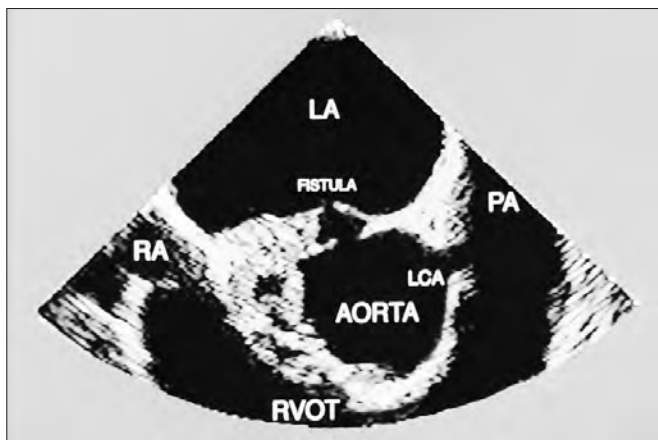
Transesophageal echocardiography showing the aorta to left atrial fistula. LA = left atrium, RA = right atrium, RVOT = right ventricular outflow tract. LCA = left main coronary artery, PA = pulmonary artery.
